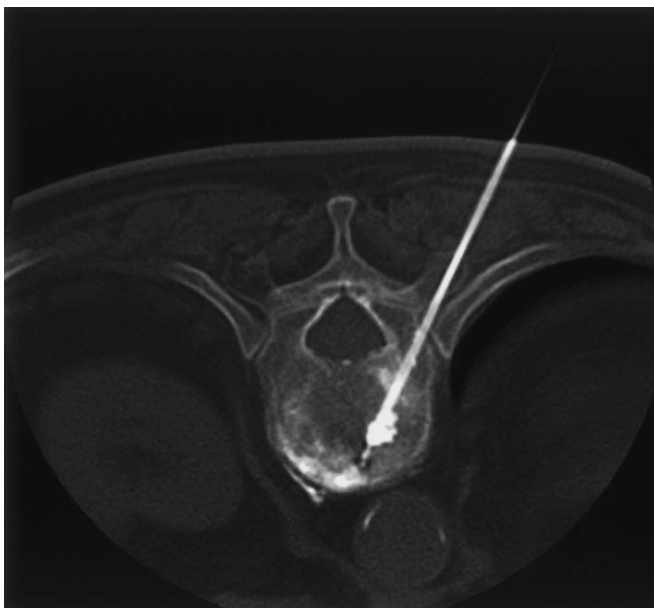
CT during surgery. Needling into the thoracic vertebra via the rib and transverse process is useful, as demonstrated in this patient.
